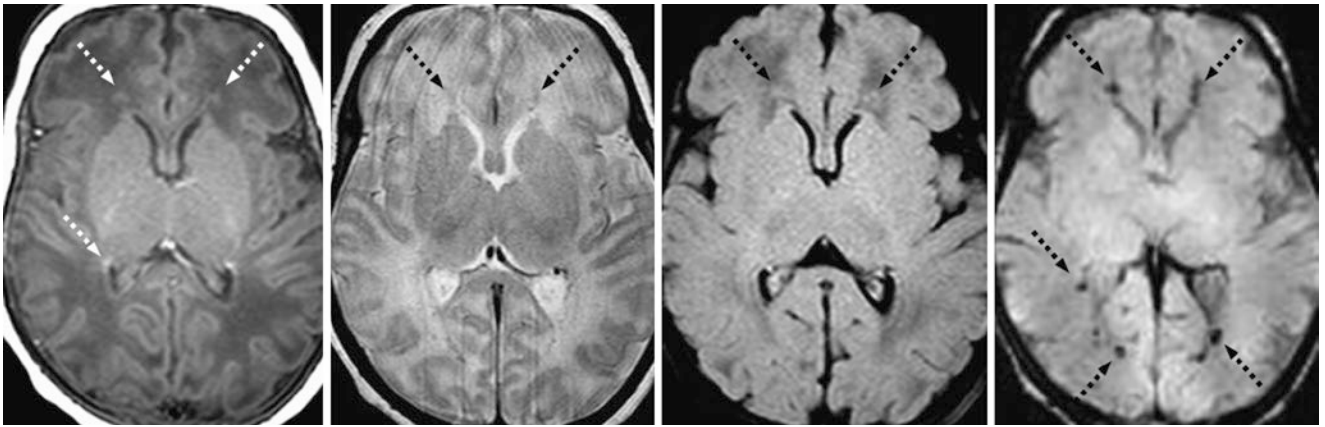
Comparison case of early sequelae of PVL. A 4-week-old premature infant had a 3T MRI at term-equivalent age that showed PVWM foci (*dotted arrows*) along the periatrinal and frontal horns on
